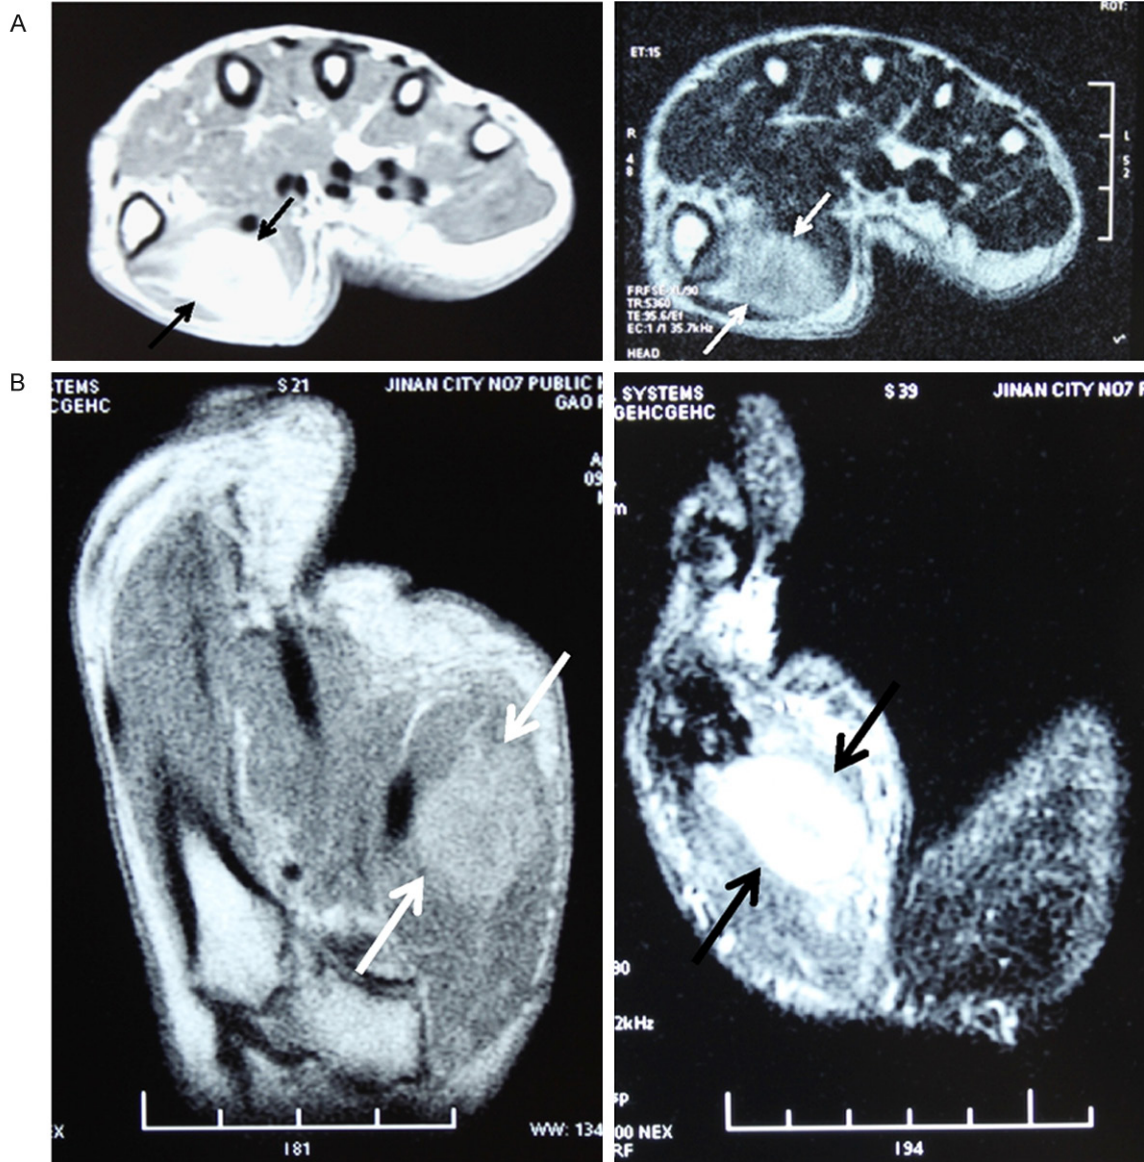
Magnetic resonance imaging (MRI) to the right hand revealed a well-defined enhanced mass in the right thenar muscle. A. Transverse section. B. Longitudinal section.
